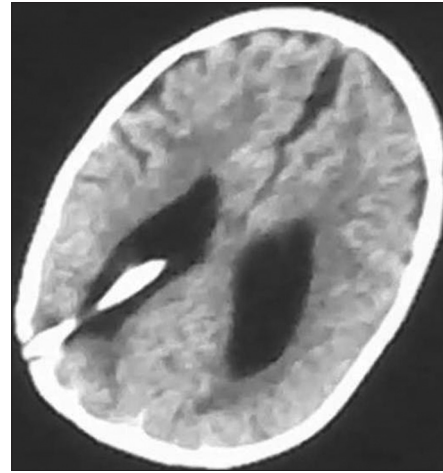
CT head showing shunt tip in situ with well-decompressed ventricles. Note the sulci can be seen well
